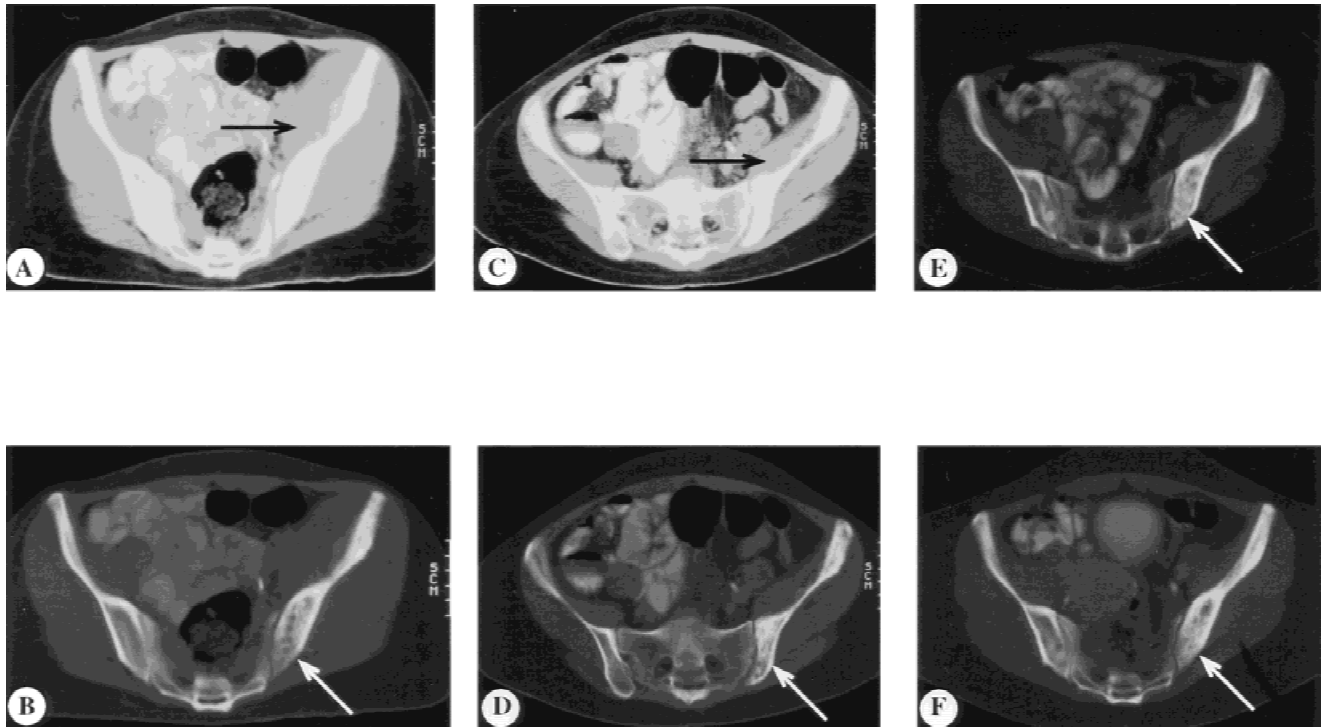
Computed tomographic images of the pelvic involvement of patient UN-1. Soft tissue (A) and bone windows (B) at diagnosis; Soft tissue (C) and bone windows (D) after three cycles of chemotherapy. Black arrows show regression of the soft tissue abnormality. Images (E) and (F) were taken at 2.2 and 2.8 years, respectively, following the start of treatment. The white arrows show the persistent bone defects.
